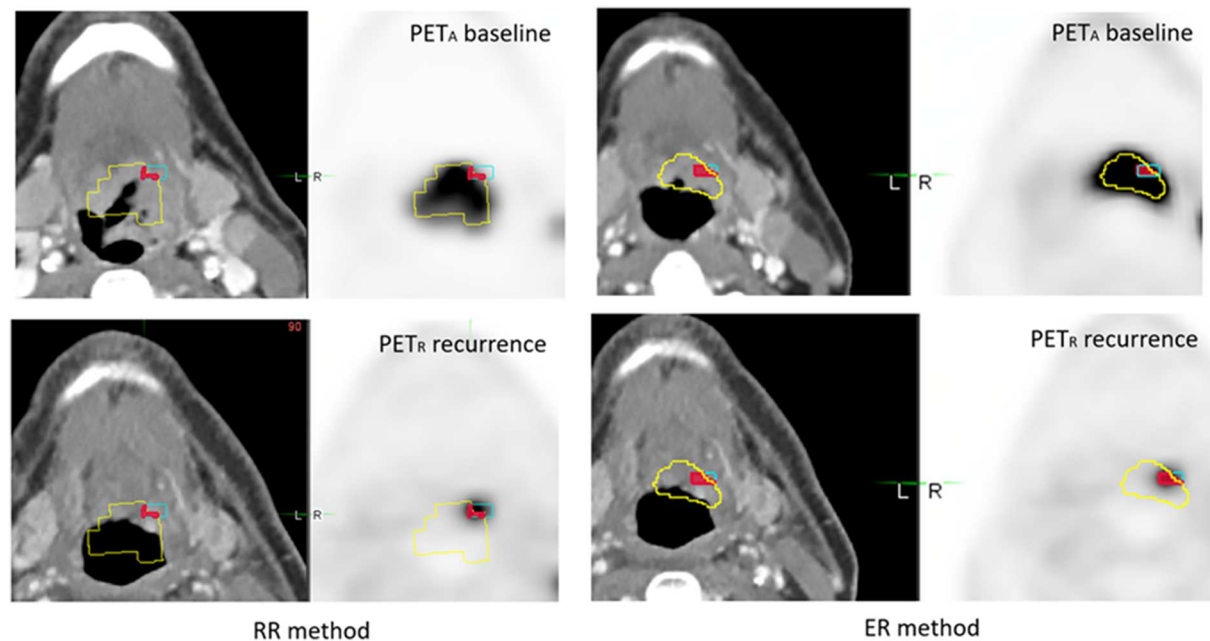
Example of 56 year-old woman with T4N2M0 oropharyngeal squamous cell carcinoma. A therapeutic response assessment by PET/CT was performed 3 months after chemo-radiotherapy, showing persistent disease. PET_A (images on the top) and PET_R (images on the bottom) were scanned in treatment position (TP) and coregistered with RR method (left) and ER method (right). A₄₀ subvolume is represented as a yellow line, R₄₀ subvolume as a blue line and A₄₀ ∩ R₄₀ in red area. The OF (A₄₀, R₄₀) index was calculated, respectively at 0.50 and 0.51 for RR and ER registration methods.
